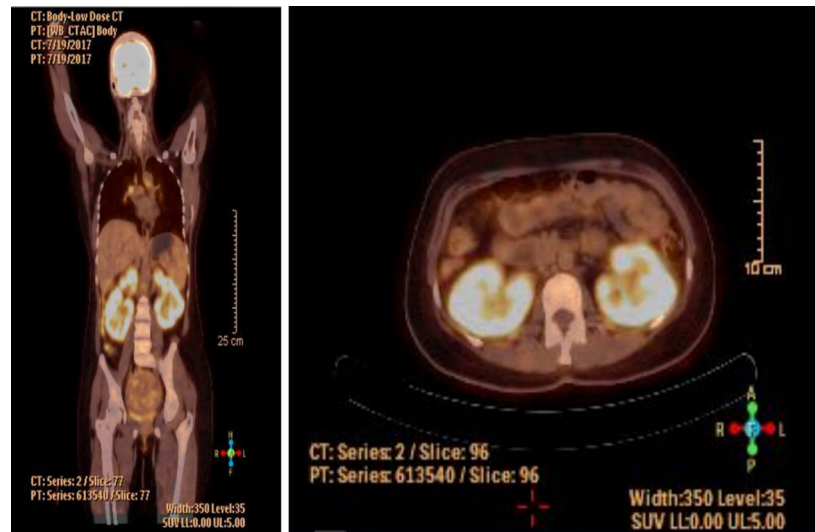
Positron-emission tomography-computed tomography scan reported as increased fluorodeoxyglucose uptake in infiltrative soft tissue areas in both kidneys (standardized uptake value max: 8.01).
